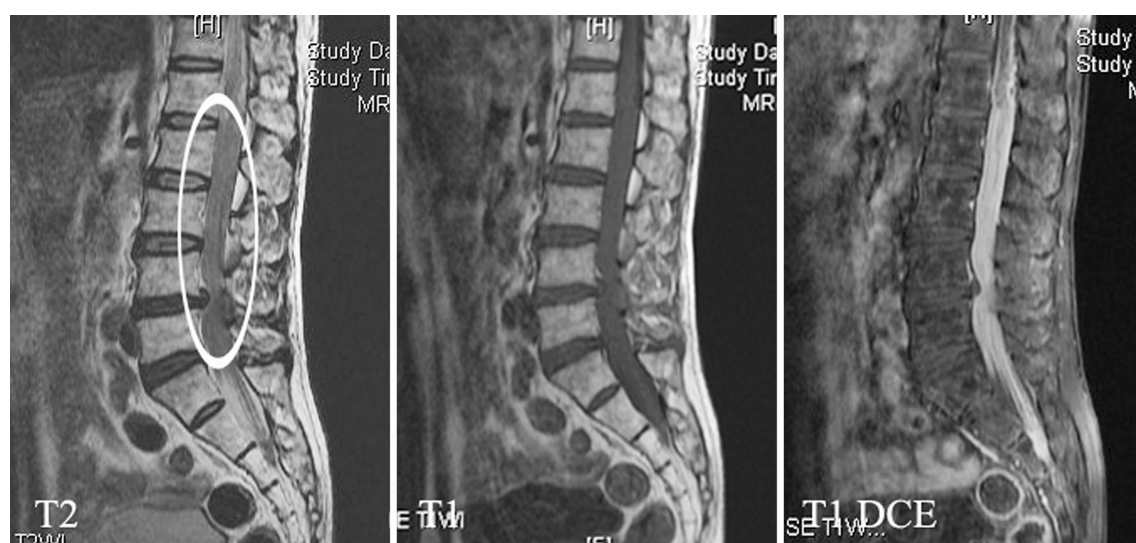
Preoperative sagittal MRI images (T2, T1-weighted, and T1-weighted enhanced images) (white oval showed all cauda equina with infiltration of hemangioma without clear margin)
